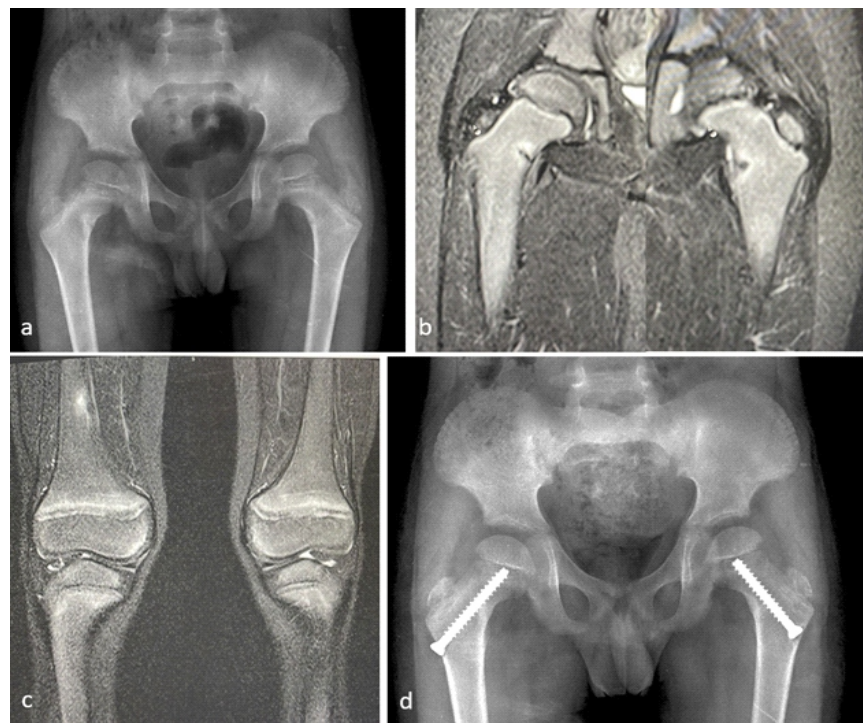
a. M/8 years (Patient no 13) with bilateral insufficiency fracture neck femur with signs of active rickets, b. MRI showing bilateral insufficiency fractures in inferior neck, c. Right distal femoral shaft showing signal changes suggestive of Looser's zone, d. X-ray one month after percutaneous single screw stabilization
